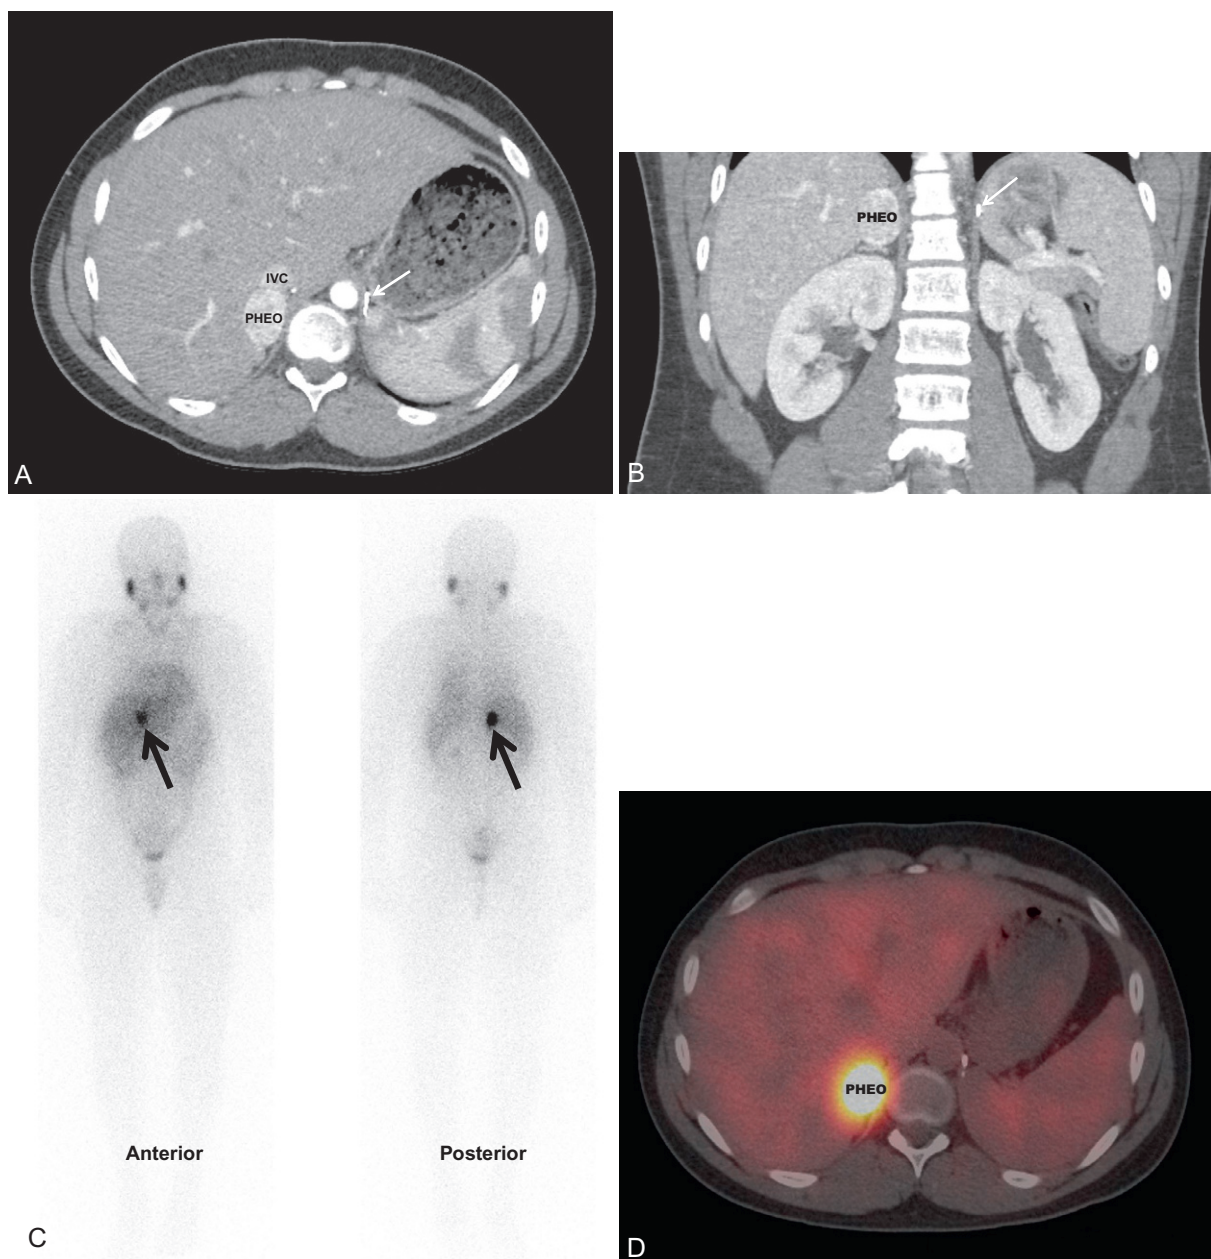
A normotensive 14-year-old male with von Hippel-Lindau disease and a history of a left pheochromocytoma and abdominal paraganglioma diagnosed at the age of 7 years was found to have elevated normetanephrine levels after screening. Axial computed tomography (CT) postcontrast (A) with coronal reconstruction (B) identified a vascular neoplasm arising from the superior right adrenal gland (arrow, surgical clips from previous adrenalectomy). Metaiodobenzylguanidine (MIBG) scan confirmed the functional nature of the tumor and ruled out other synchronous tumors. Planar (C) and fused single photon emission CT/CT axial images (D) in the same patient, 24 hours after the administration of ¹²³I MIBG. IVC, Inferior vena cava; PHEO, pheochromocytoma.
